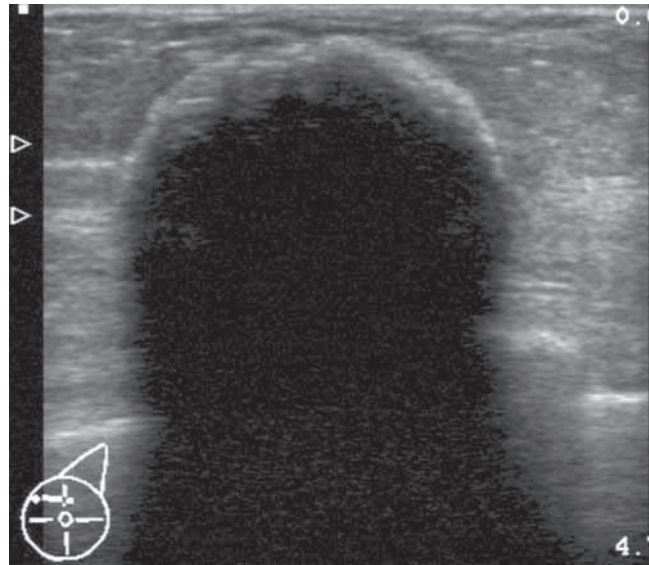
Cryoablation. The needle is placed through the center of the lesion, and argon gas is delivered to create a local temperature of -40°C . The resulting iceball is well visualized by ultrasonography.
